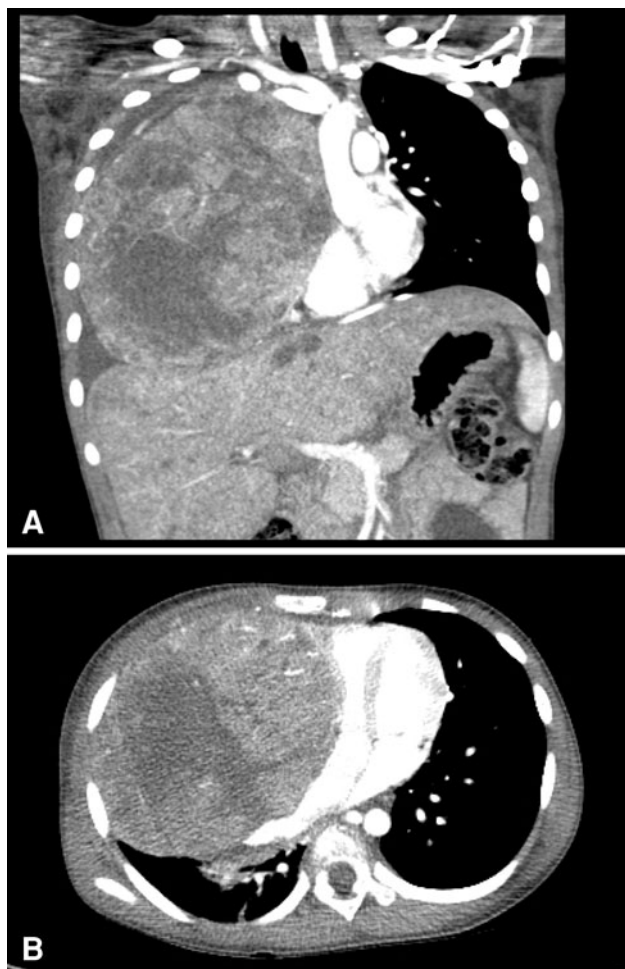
Coronal (A) and axial (B) views of a computed tomography scan of the chest showing significant compression of the heart and mediastinal structures
